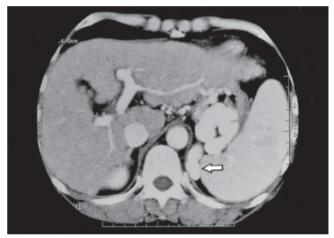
Gastric varices and gastrorenal shunt (*arrow*), as the outflowing vessel, were detected with CT
